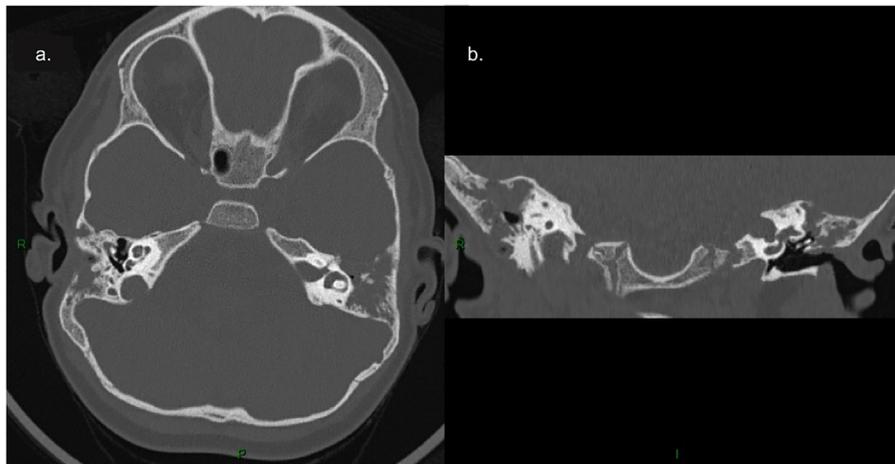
Unenhanced temporal bone CT scan, (a) axial section, (b) coronal section.
